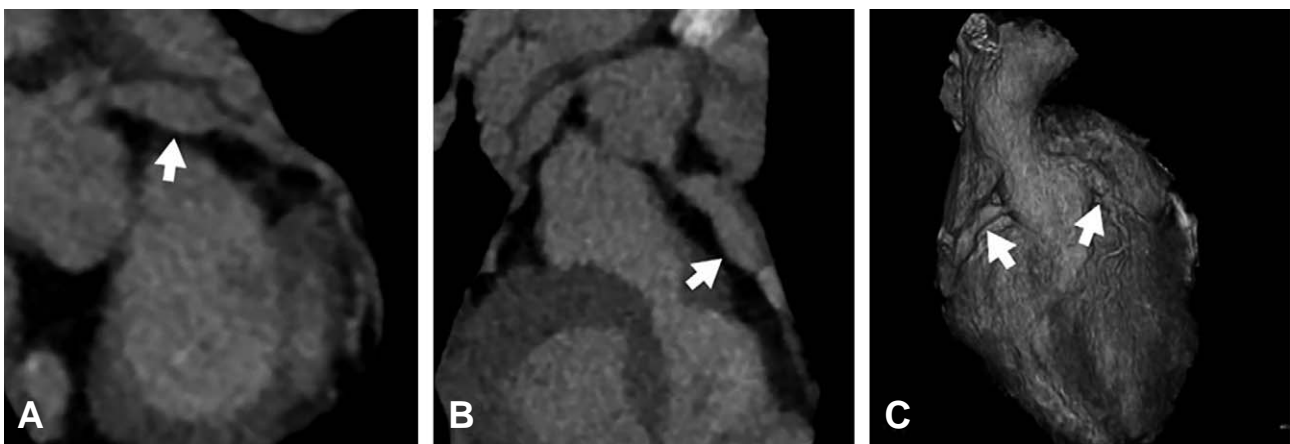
Cardiac computed tomography findings after the second therapy. It shows a spindle-shaped coronary ectasia of the left main coronary artery (arrow; length, about a bit more than 2.0 cm; diameter, 6.2 mm; Z-score = 6.1) (A) and a long fusiform aneurysm of the right coronary artery (arrow; length, about 3.6 cm; diameter, 6.7 mm; Z-score = 5.6) (B). These findings are also seen in a 3-dimensional reconstruction image (arrows; C).
